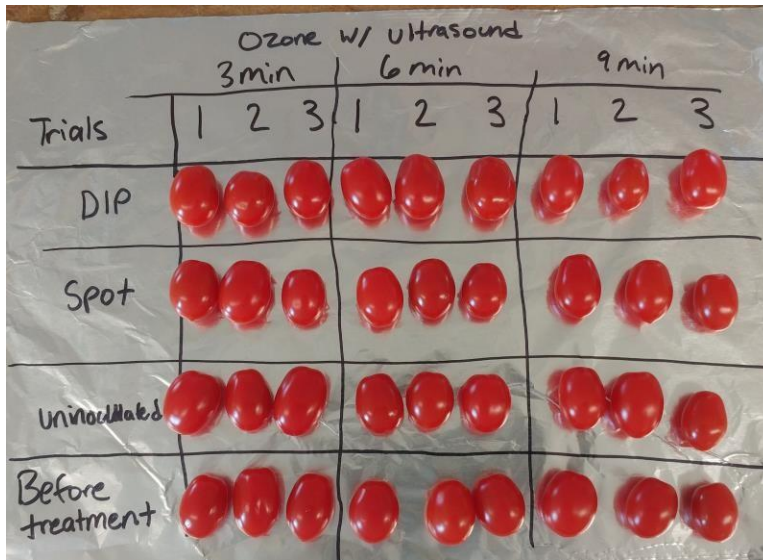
Picture showing how ozone and ultrasound apparatus (shown in Figure 2) impacted the tomato samples. Dip-and-spot-inoculated tomatoes, uninoculated tomatoes, and untreated tomatoes (200 g) were placed within the bin full of water to be washed and sanitized by ozone and ultrasound in alternating bursts. They appear intact; although, their texture was altered.
